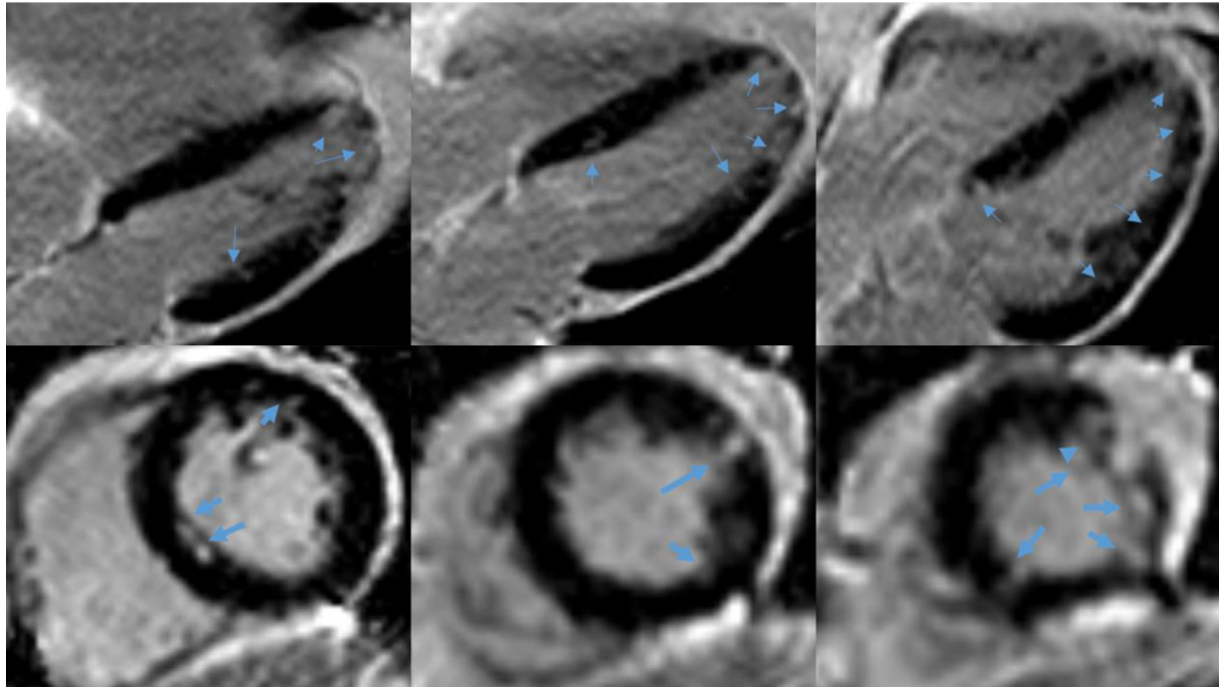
Repeated cardiac MRI after 3 months showing multiple scars on 4-chamber views and short axis views.
